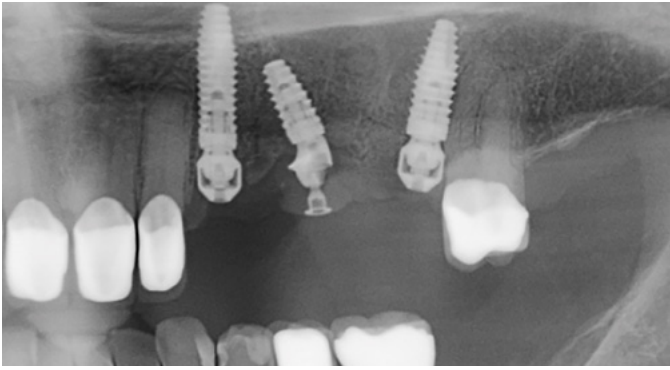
Immediate post-op radiograph confirming implant and abutment seating
